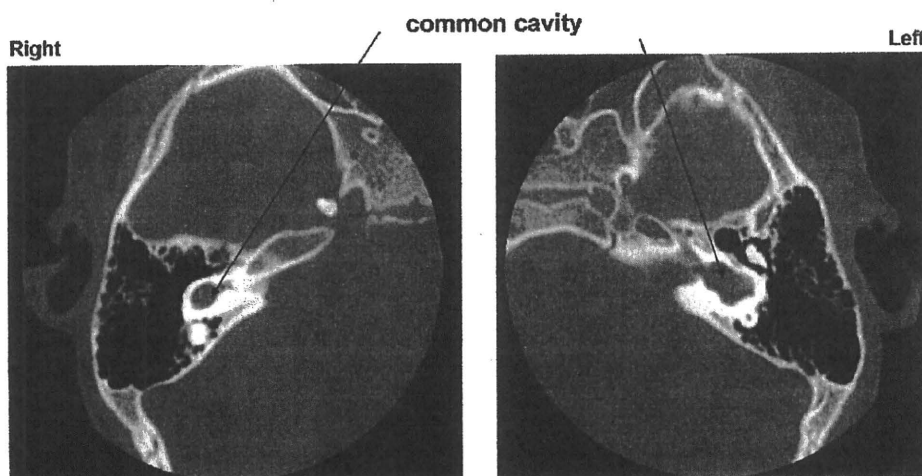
CT scan showing common cavity in case 3.
